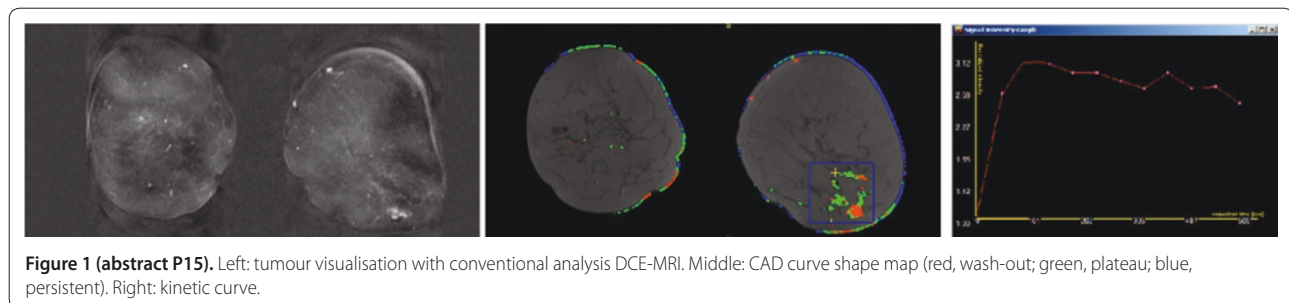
(abstract P15). Left: tumour visualisation with conventional analysis DCE-MRI. Middle: CAD curve shape map (red, wash-out; green, plateau; blue, persistent). Right: kinetic curve.
